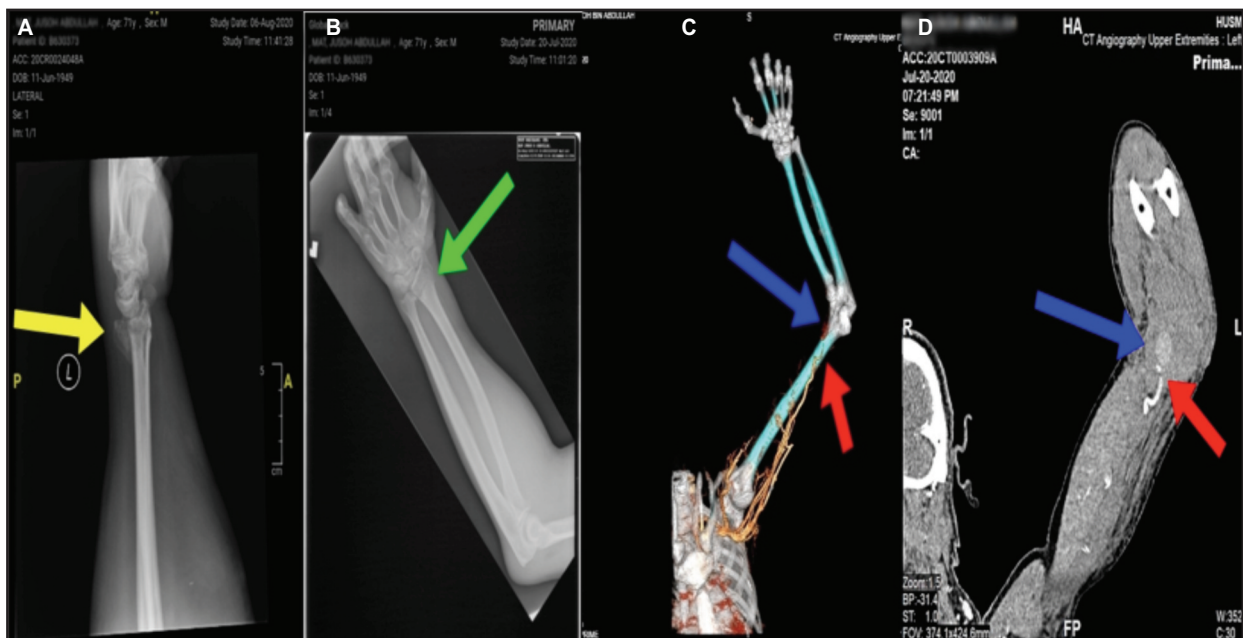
Yellow arrow shows dorsal angulation of distal end radius on the lateral view of radius-ulna radiograph. The green arrow shows a linear fracture of the distal end radius on the anteroposterior Radius-Ulna radiograph. The red arrow shows abrupt non-opacification to the distal of the left brachial artery, while the blue arrow shows contrast extravasation adjacent to the distal brachial artery which appears to be connected to the injured vessel on the volume rendering technique reconstruction image and coronal reconstruction image of the left upper limb computed tomography angiography.
